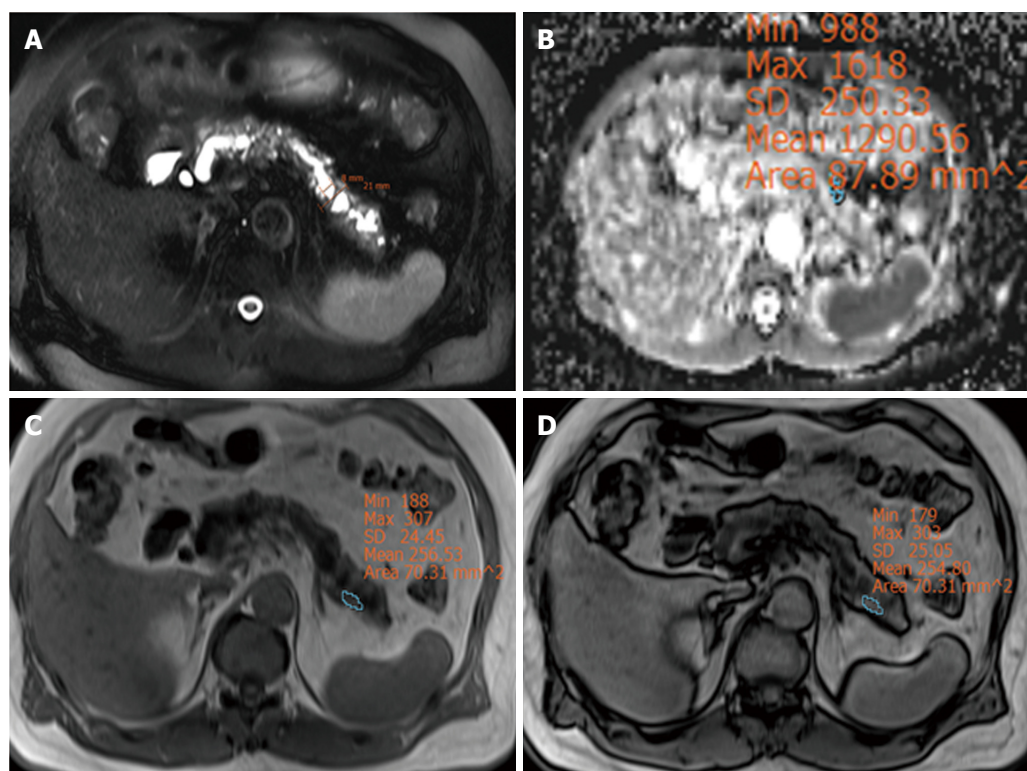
Pancreas cancer with a hard pancreas. Magnetic resonance imaging of a 66-year-old male with pancreas head cancer who was found to have a hard pancreas (durometer measurement: 18 DU). The diameters of the pancreatic duct and parenchyma were 8 mm and 21 mm, respectively (A). The apparent diffusion coefficient value of the pancreatic parenchyma was 1.290 mm²/s (B). The signal intensity of the pancreas on in-phase imaging was 256.53 (C) and on opposed-phase imaging was 254.80 (D).
